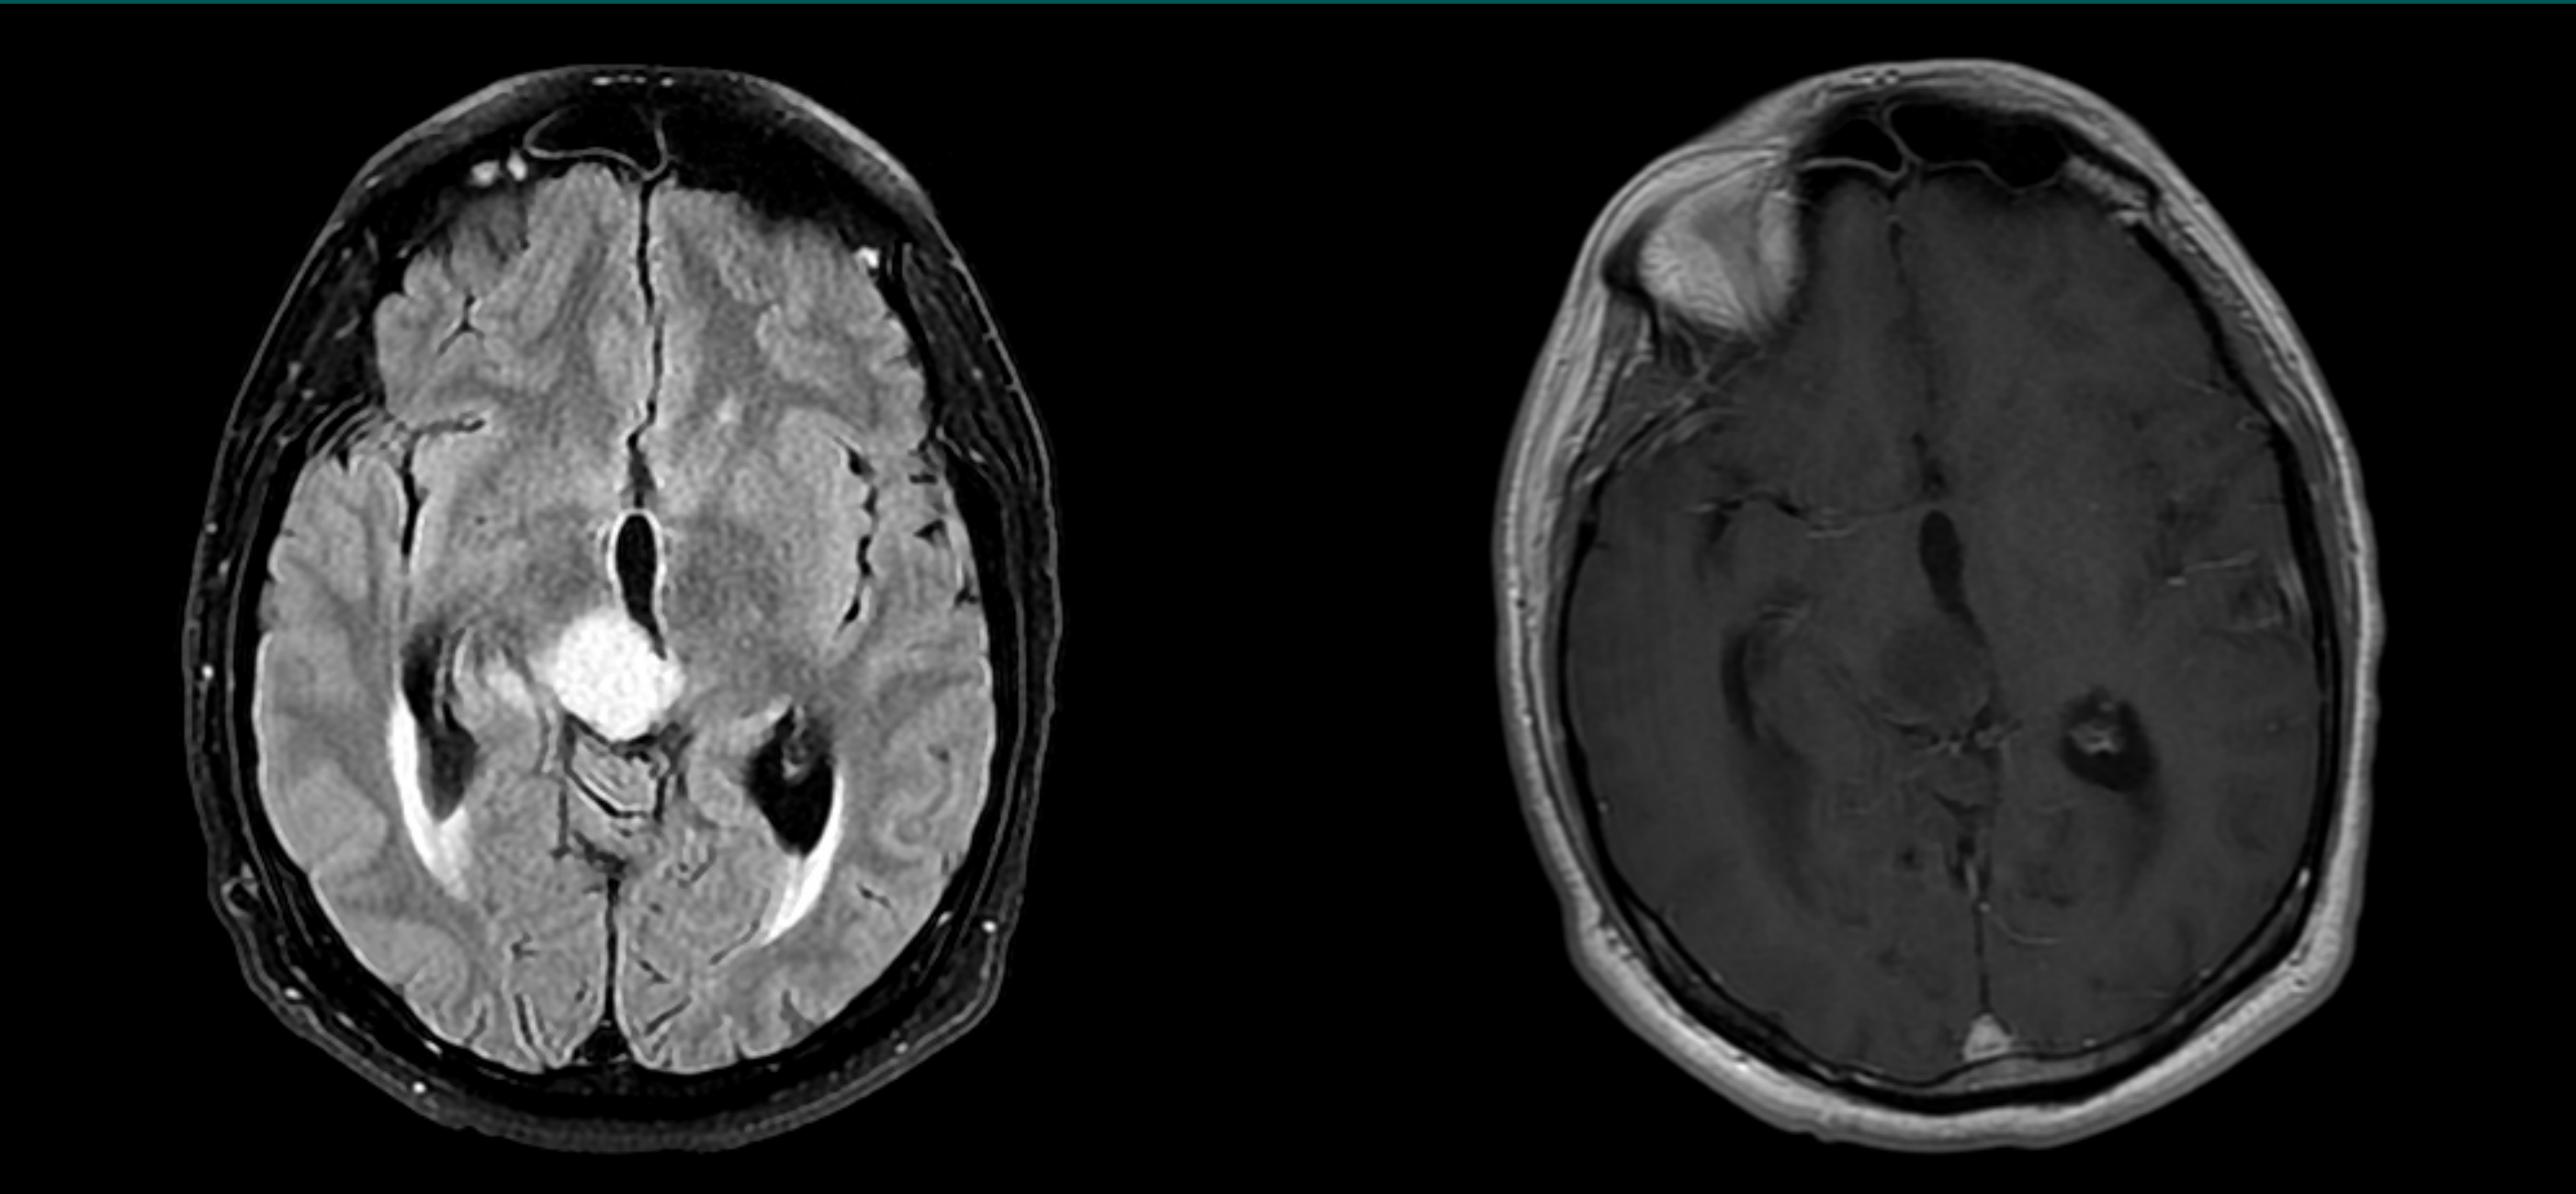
MRI brain with and without contrast showing a 2.5 cm T2-hyperintense lesion centered in the right thalamus and extending into the superior aspect of the right midbrain. There was an equivocal area of punctate enhancement along the posteromedial aspect.
